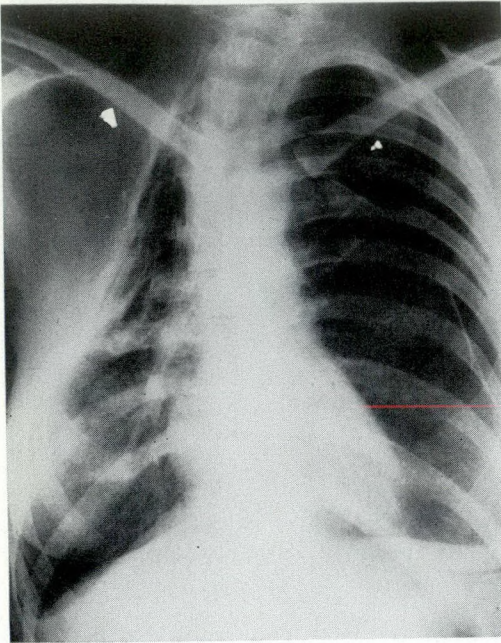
C.E. Chest radiograph February 27, 1948. On the left a successful pneumothorax has been established, on the right a standard, seven-rib thoracoplasty.
